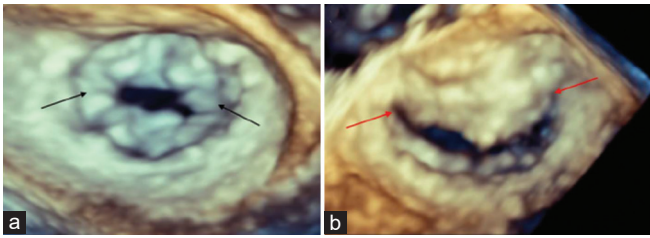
Three-dimensional transesophageal echocardiogram demonstrating the difference between rheumatic valve disease and radiation-induced valve disease. (a) Rheumatic mitral valve with bilateral commissural fusion (black arrows). (b) In contrast in radiation-induced valve disease, there is no commissural fusion (red arrows)
